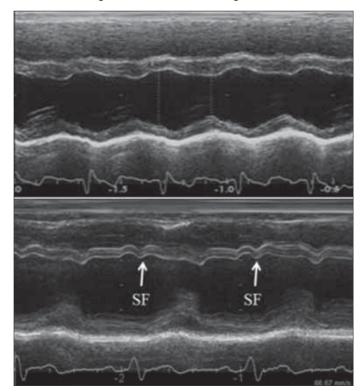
Parasternal long-axis view M-mode images of normal (above) and dyssynchronous (below) left ventricle. Using M-mode echocardiography, it is difficult to calculate septal-posterior wall motion delay, because of the presence of more than one septal motion (septal flash-SF)
